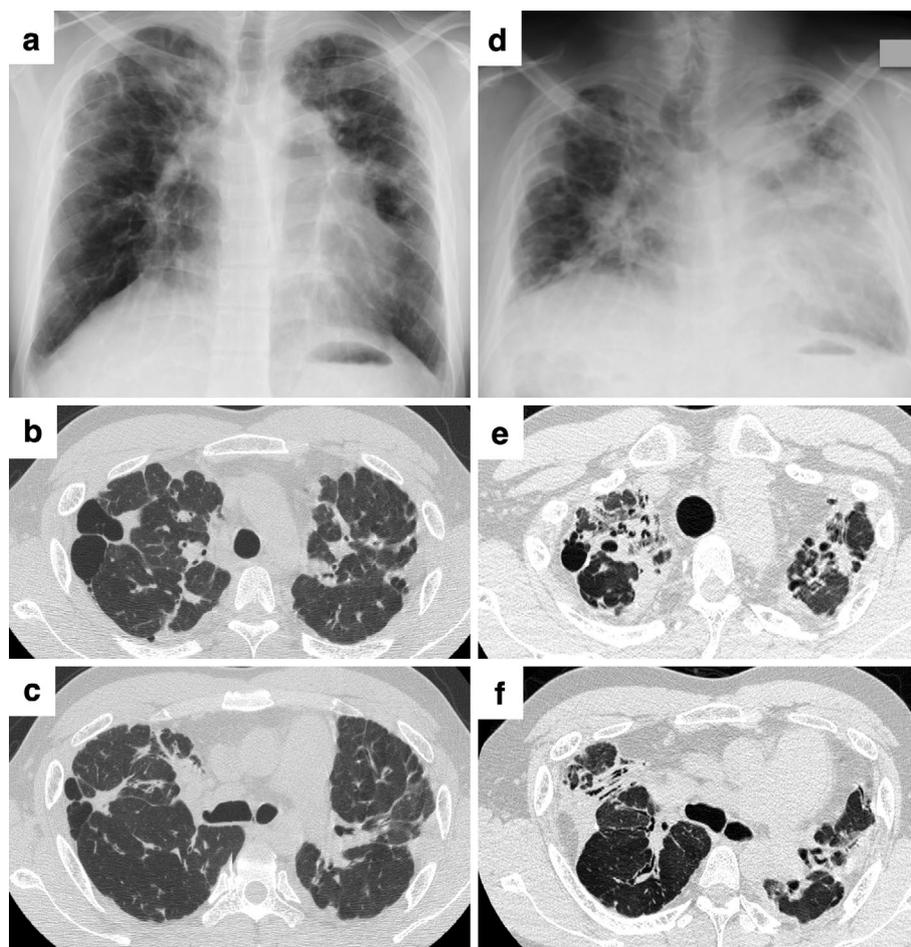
(a) A chest radiograph acquired in 2011 showing abnormal shadows and volume loss predominantly in the upper lung fields. (b, c) A computed tomography (CT) scan of the chest obtained in the same year showing high-density shadows along the bronchovascular bundle and in the subpleural area. (d) A chest radiograph from 2016 shows progression of the abnormal shadows and volume loss, predominantly in the upper lung fields, with tracheobronchial tortuosity. (e, f) A CT scan of the chest, also from 2016, showing further progression of the high-density shadow along the bronchovascular bundle in the subpleural area, again predominantly in the upper lung fields.
